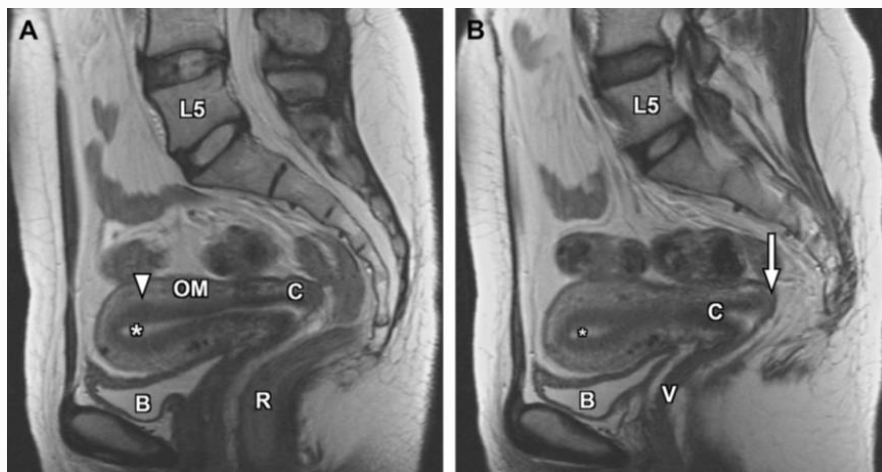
Sagittal T2-weighted images of the female pelvis in midline (A) and Para midline (B) locations. The zonal anatomy of the uterus is well demonstrated on T2-weighted images, with high signal intensity in the endometrium (asterisk) and characteristic low signal intensity of the junctional zone (arrowhead). Outer myometrium demonstrates intermediate signal intensity between the two other uterine layers. The cervix is well seen in longitudinal dimension, noting contiguity of the dark fibromuscular stroma with the uterine junctional zone. The posterior fornix (arrow) is formed from the posterior reflection/interface of the exocervix and the vagina. B, bladder; C, cervix; L5, L5 vertebral level; OM, outer myometrium; R, rectum; V, vagina (*Wasnik et al., 2011*).
